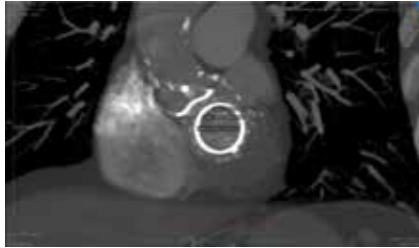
CT image demonstrating the distance between the aortic and mitral rings. Minimum distance was 0.4 cm and the maximum distance is 0.7 cm.
